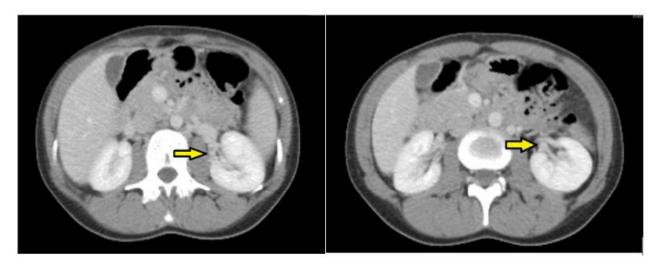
A bifid collecting system emerging from the left kidney is seen in CT urography transverse sections.
